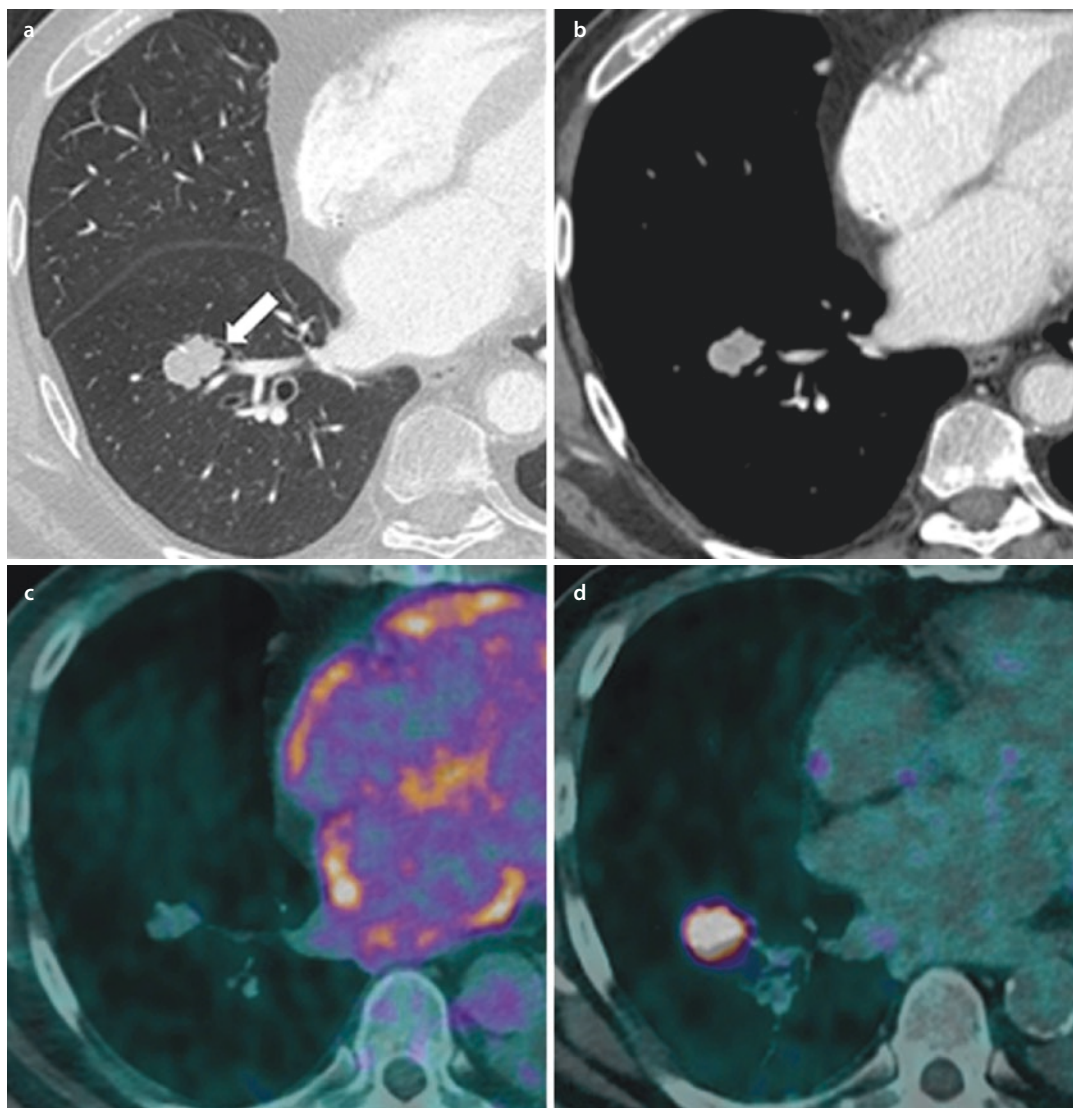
Axial chest CT image in the lung window setting a of a solid nodule with lobulated margins in the anterior basal segment of the right lower lobe, showing both endobronchial (*arrow*) and extrabronchial intraparenchymal growth. Mediastinal window setting b demonstrates homogeneous contrast enhancement.
